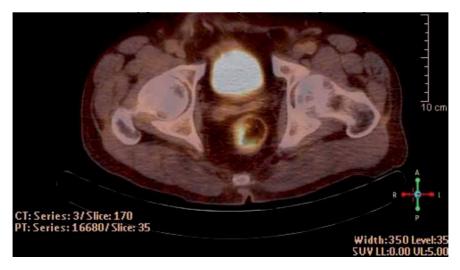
PET/CT of rectal cancer.*
